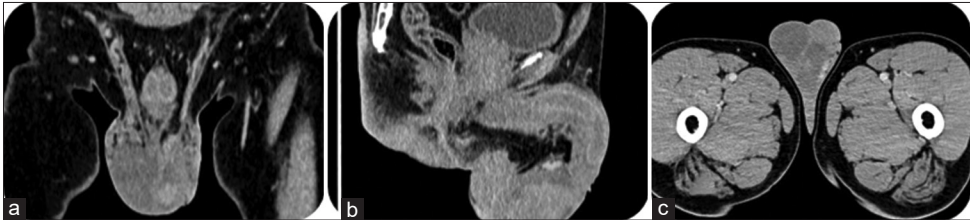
Computed tomography scan images showing a well-defined enhancing hypodense lesion in the left testis, suggestive of a testicular mass, with no evidence of inguinal lymphadenopathy (a) Coronal view, (b) Sagittal view and (c) Axial view (Case 2)
